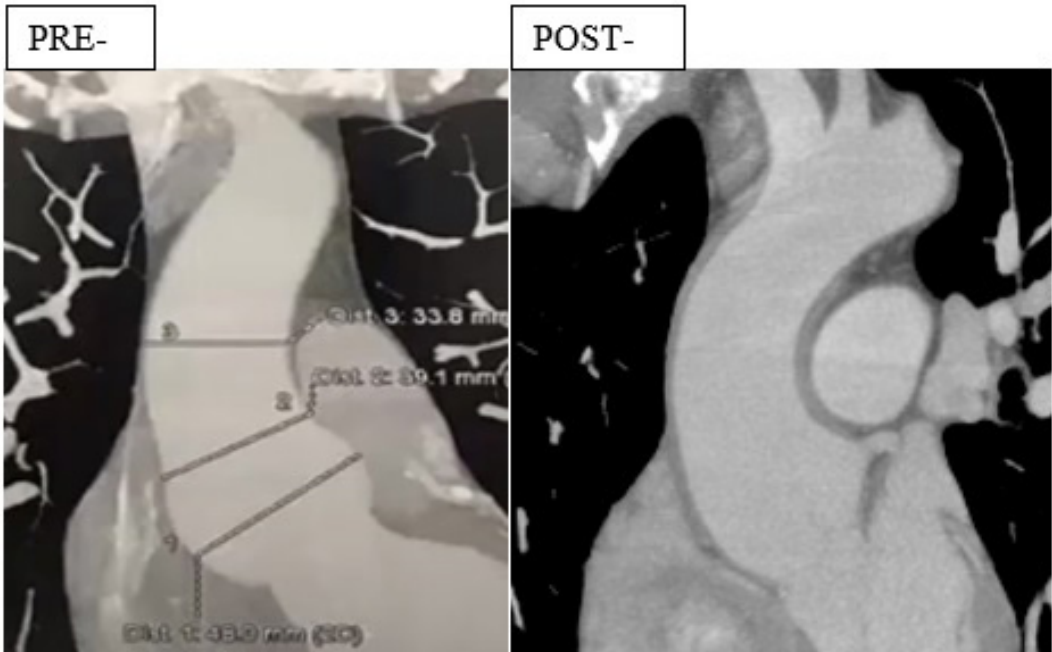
Preoperative and one-year postoperative computed tomography angiography of the first case in this series, a 41-year-old male patient with FBN1 mutation confirmed Marfan's syndrome, aortic root aneurysm with 48 × 48 mm diameter, and mild aortic insufficiency that was completely corrected by the implanted graft. Immediately and one year postoperatively, there was no aortic regurgitation at echo examination and the aorta was stable at 44 × 44 mm maximum diameter at the sinuses. Observe the shadow of thickening of the aortic wall determined by the implanted graft, from the aortic ventricular junction, below the sinuses of Valsalva, up to the origin of the brachiocephalic trunk and the near normal postoperative aortic shape.
